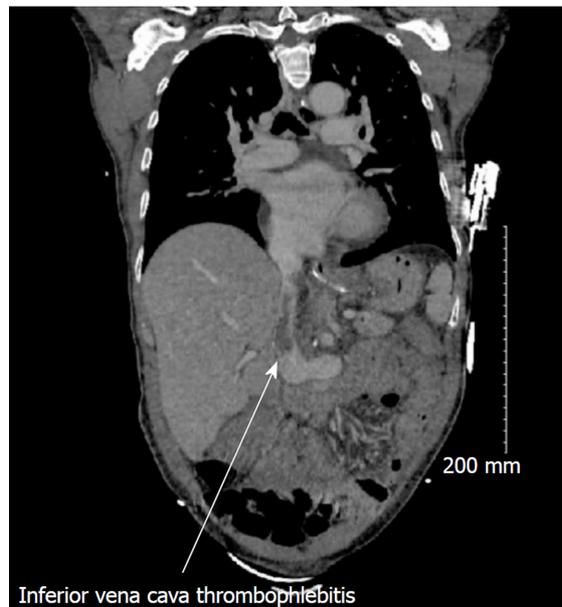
Coronal computed tomography scan of thrombophlebitis of the vena cava after hepatectomy.
